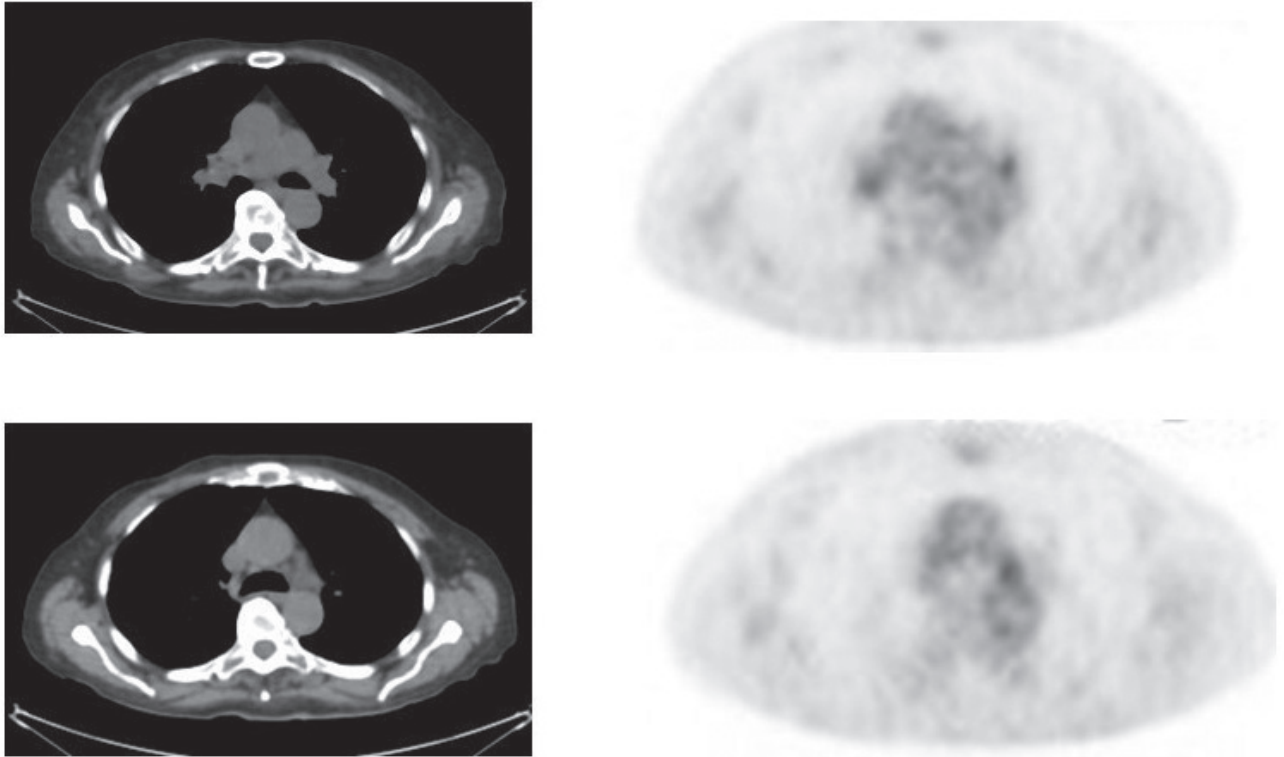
Low-grade uptake (SUV max=3,6) of small lymph nodes in left hilum and aortopulmonary space.
